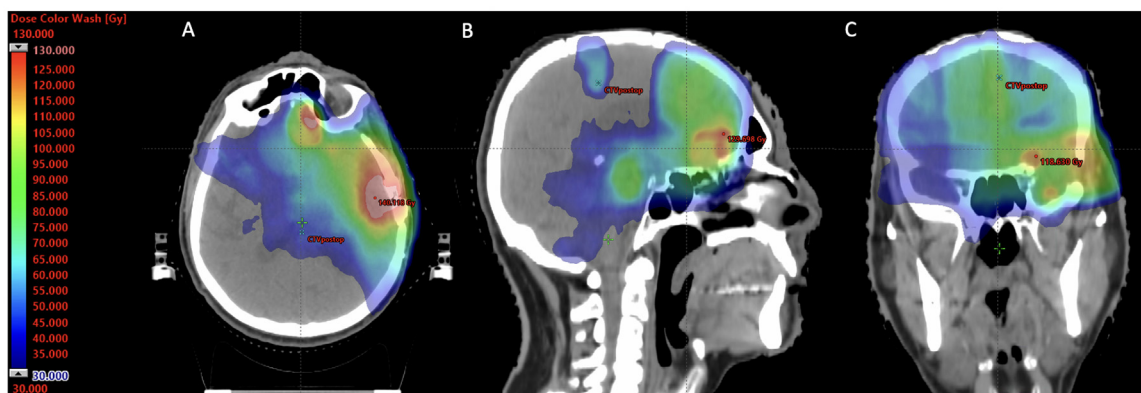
Sum plan of treatments with photons and dose distribution from 2006 until 2021. Magnetic resonance imaging planes. (A) Axial, (B) sagittal, (C) coronal. Rainbow color-coded dose distribution indicates highest doses in the left temporal and left frontal areas. Large areas of the brain were spared from significant radiation dose.
